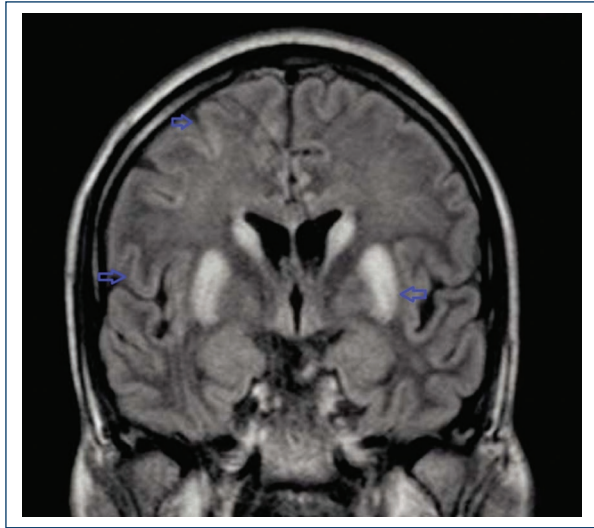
Magnetic resonance imaging coronal section in fluid-attenuated inversion recovery in addition to hyperintensity in basal ganglia and dedifferentiation of gray and white matter, generalized cerebral edema is observed, giving an image of atrophy of the grooves.
